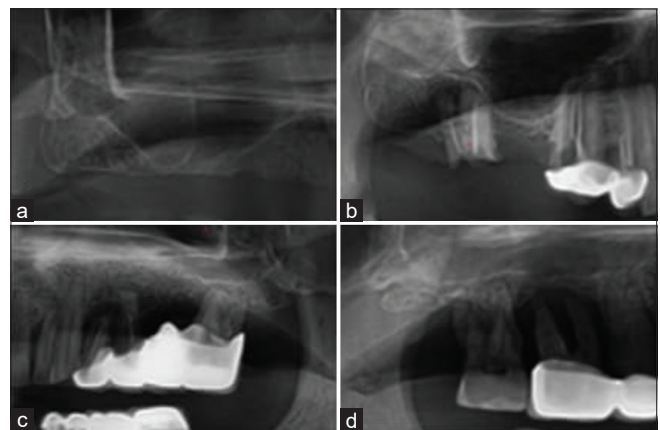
Pterygoid anatomic radiographic prediction (PARP) classification. (a) PARP I, (b) PARP II, (c) PARP III and (d) PARP IV
